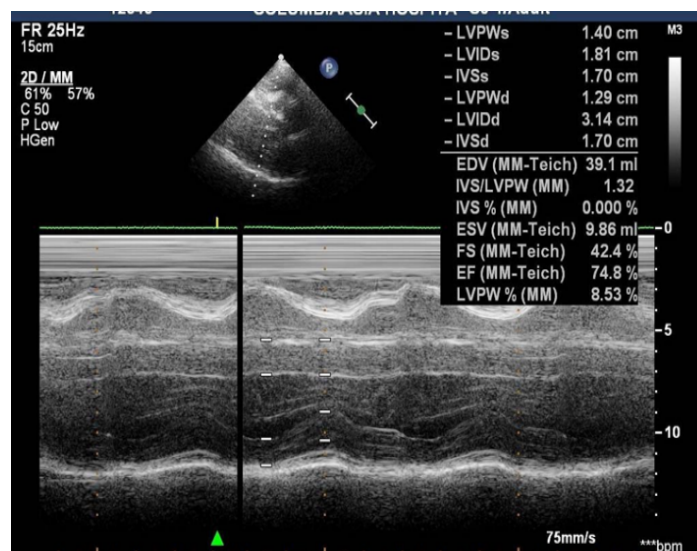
Echocardiography showing the measurement of Gradients in Left Ventricular Hypertrophy
